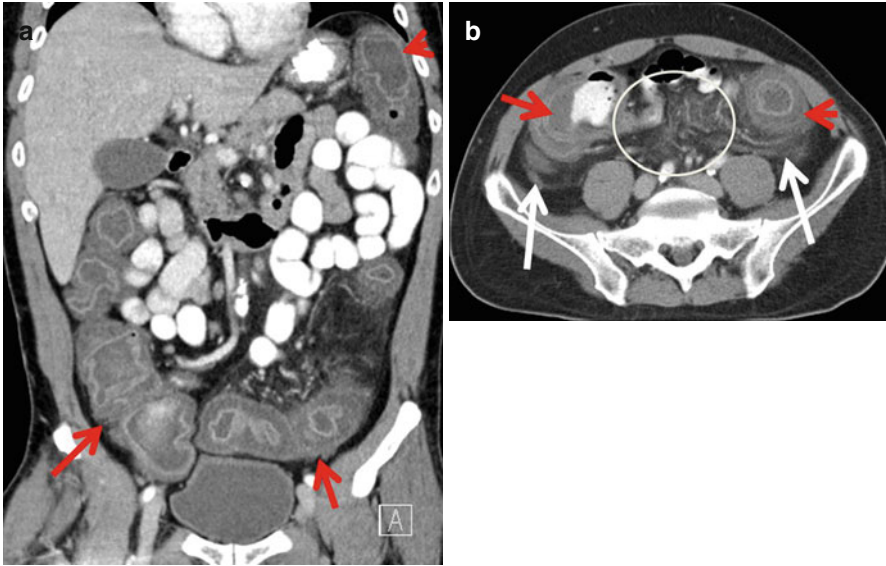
Axial (a) and coronal (b) iv contrast enhanced CT images demonstrate diffuse marked colonic wall thickening and mucosal enhancement (*red arrows*) with adjacent mesenteric stranding (*white arrows, white circle*), which can be seen with severe acute colitis. Note that similar imaging findings can be seen in severe cases of colitis from other infectious etiologies as well as non-infectious etiologies, as in Ulcerative Colitis, or less likely in infiltrative neoplastic processes such as lymphoma
